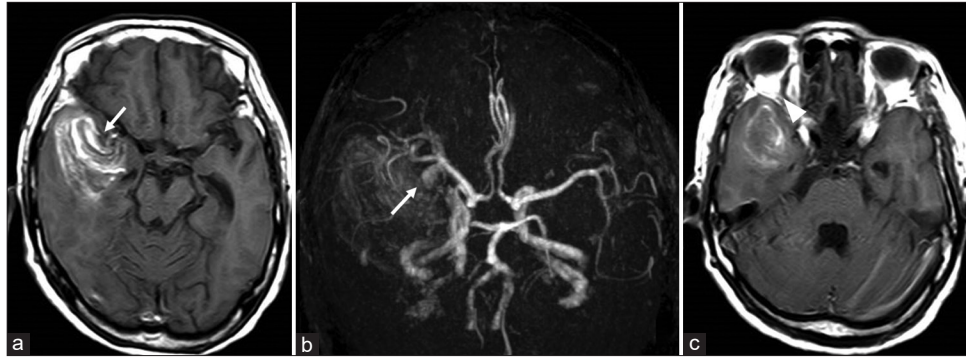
(a) T1-weighted magnetic resonance imaging showing intracerebral hemorrhage and a rounded mass in contact with the right middle cerebral artery (arrow). (b) MR angiography showing an aneurysmal rounded mass arising from the middle cerebral artery bifurcation (arrow). (c) T1-weighted magnetic resonance imaging showing a dilated right superior orbital vein (arrowhead).
